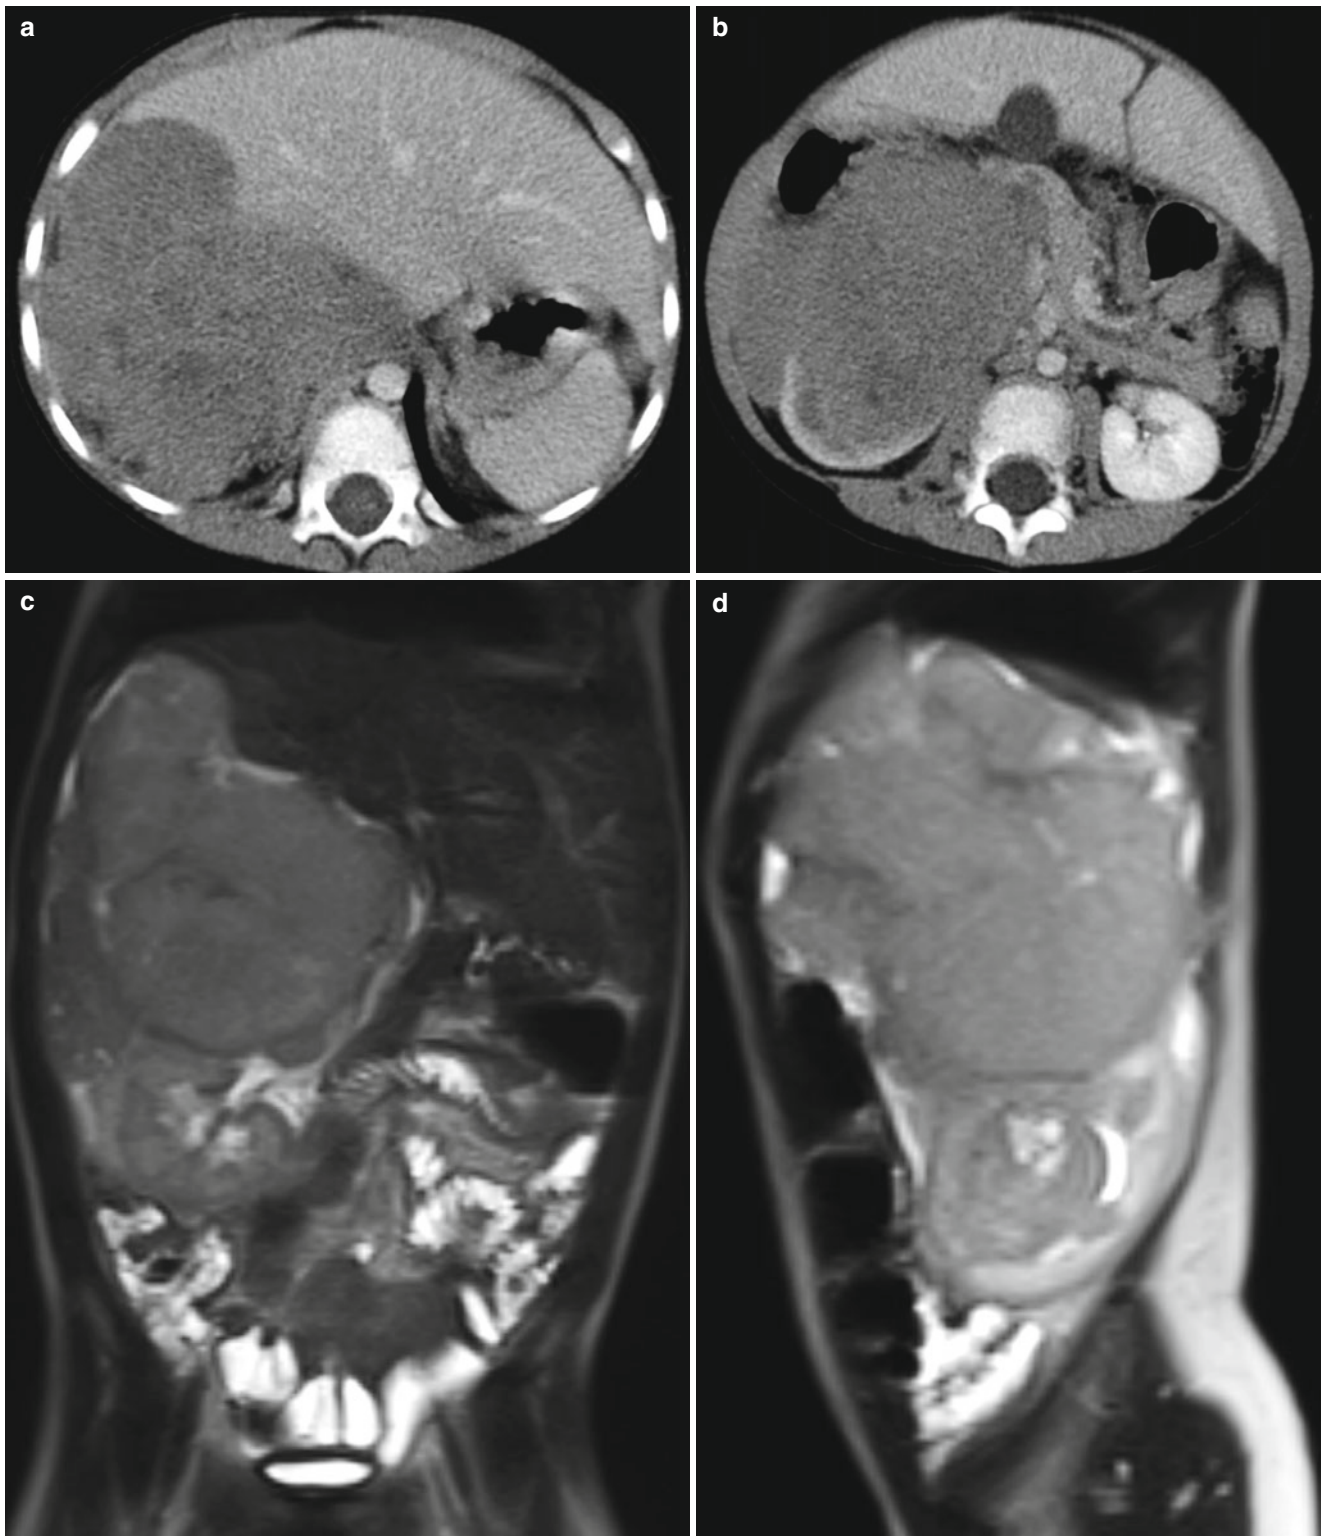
Wilms tumor in a 2-year-old boy. (a and b) Contrast-enhanced CT scans show a large enhancing mass arising from the right kidney and extending into the right subhepatic and perirenal spaces. (c and d) T2-weighted axial MR images demonstrate a large
